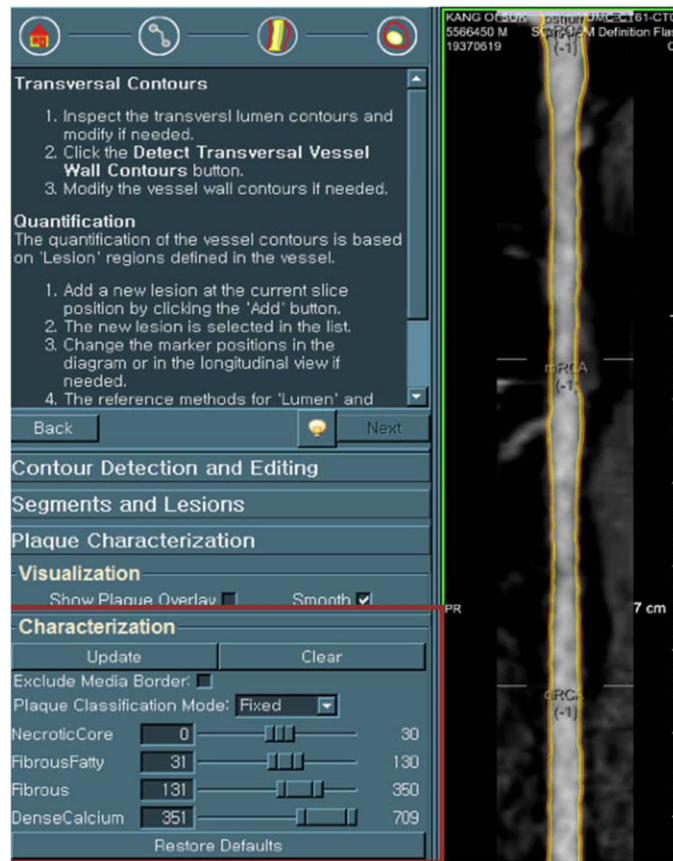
Medis QAngio-CT measurement with center-plane reformat of coronary artery.
